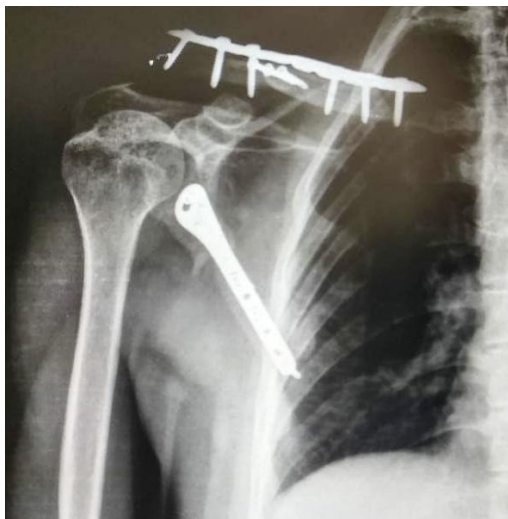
Case 2: Post-op X-ray AP view (1 plates in Scapula, GPA restored $>30^\circ$)
